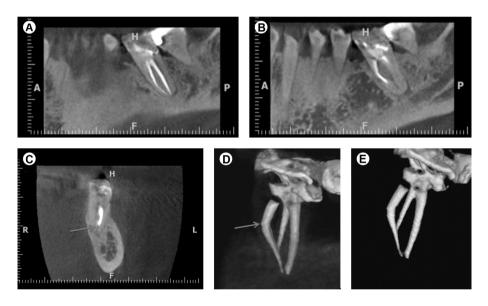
A: Sagittal CBCT view showing normal periapical status. B: Sagittal CBCT view showing the limit of obturation and the file fragment at the cervical and middle thirds of the mesiobuccal canal. C: Coronal CBCT view showing a space in the apical portion of the mesiobuccal canal (arrow), suggesting a double curvature not observed at periapical radiograph. D: 3D rebuild showing in detail the limit of obturation and the file fragment (arrow). E: 3D rebuild showing the internal configuration of the root canal fillings.
